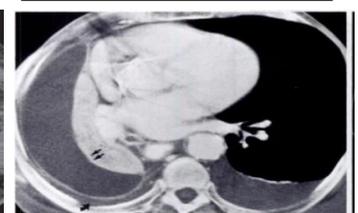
Contrast-enhanced CT scan of a chest with congestive heart failure .the right lung is collapsed, and the parietal and visceral (straight arrows) pleura are diffusely thickened. The sub pleural fat (curved arrow) is thicker than that in the left side.
